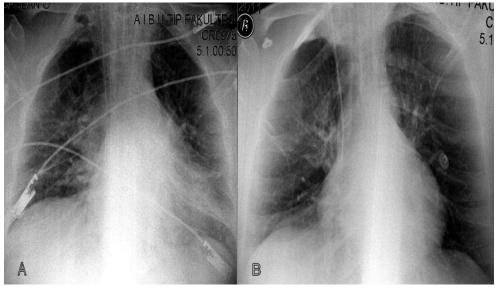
Chest roentgenogram. *A*, The image shows increased pulmonary vascularity. The X ray obtained 30 min after ICU admission. *B*, The X ray after 12 hours of ICU admission.
